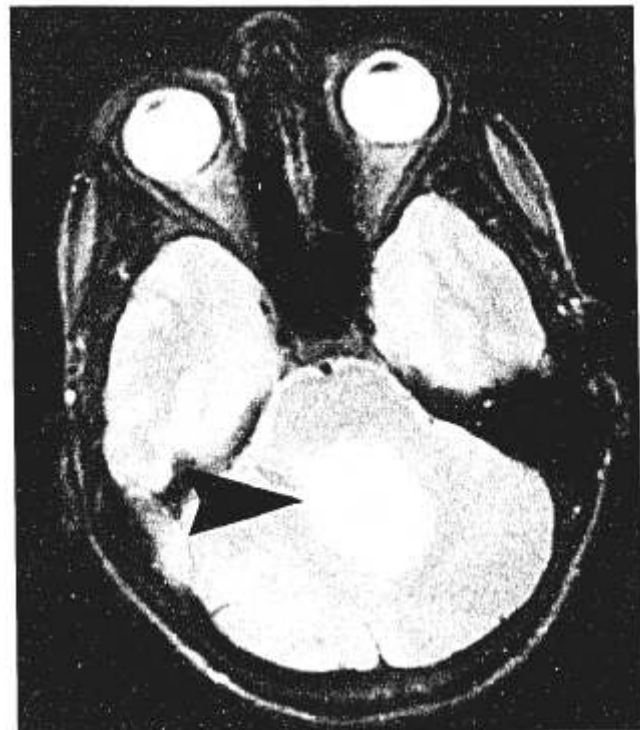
Patient 5. MRI scan showing a central cerebellar tumor. The patient had bilateral saccade overshoots and large alternating saccades during attempts at fixation.
